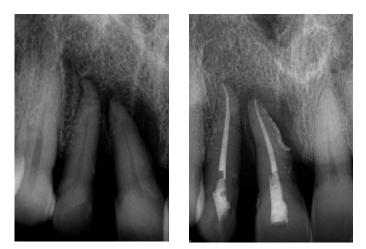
Pre-op teeth Nos. 7 and 8 with bone loss and periapical radiolucency, increased mobility, and probing depth (left). Figure 8: Teeth Nos. 7 and 8 with root canal therapy completed and No. 8 with intentional sealer puff. Tooth No. 8 was managed surgically with incision, drainage, and curettage (right)
